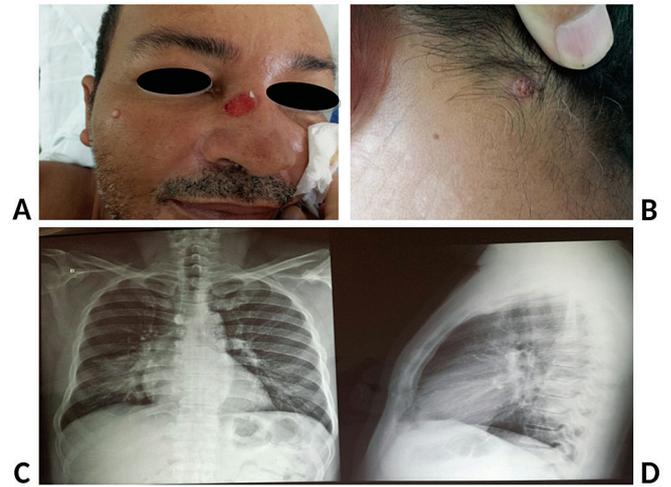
Clinical and X-ray evaluation of the patient
